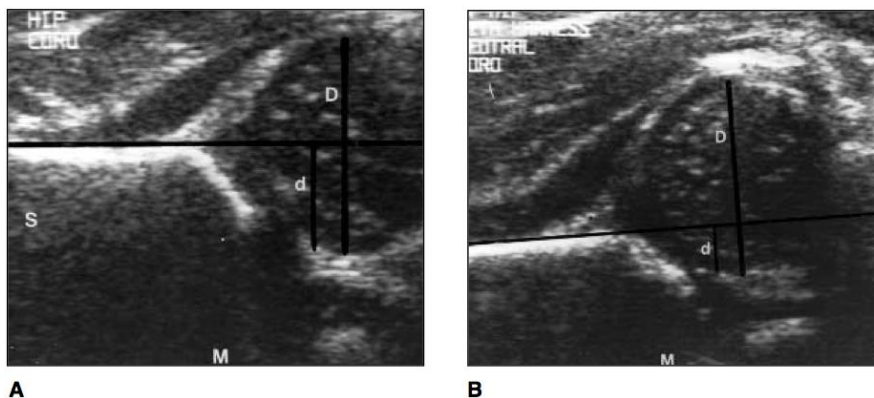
Coronal ultrasound of an immature, subluxed hip. The promontory is slightly rounded and approximately 25% of the femoral head is within the bony acetabulum. The left femoral head is decentred
